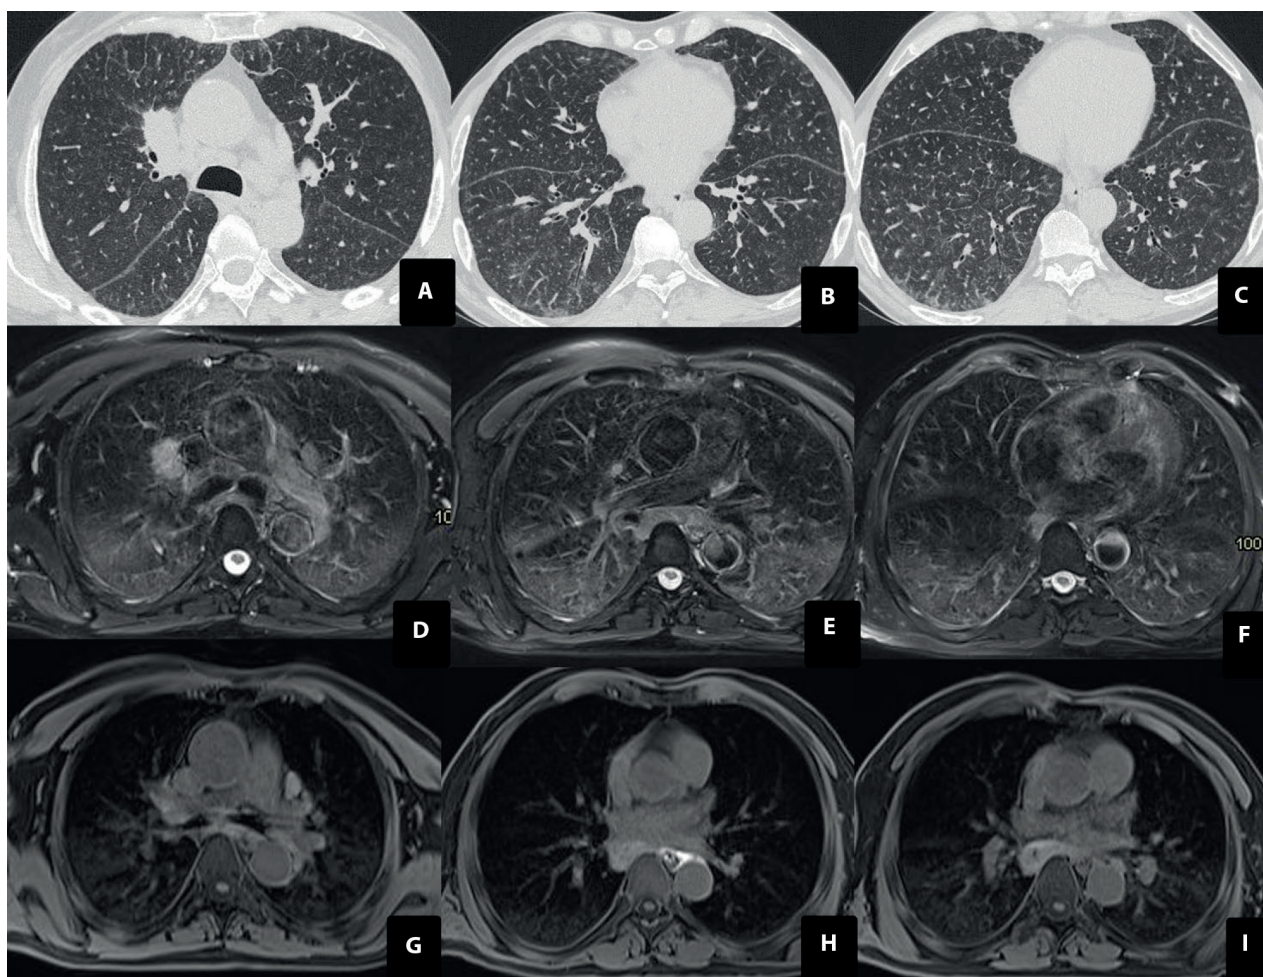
CT scan (a-c): nodular lesion is present in the right hilum, likely related to adenopathy. Mildly, diffusely thickened the interlobular septa, mainly in mid to lower lung zones. Mild alveolar ground glass attenuation is visible in both lower lobes. T2w- MRI (d-f): Adenopathies in the right hilar region, and mediastinum, the biggest in subcarinal region. In both lower lobes is visible a mild increase of the signal, mainly in the left lower lobe (yellow arrow). T1w-MRI sequence with fat saturation (g-i): the first T1 image (g) was acquired before the bronchoscopy and the contrast administration. The second T1-w image (h) was acquired twenty minutes after the end of the bronchoscopy with the contrast medium administration. It shows a minimal amount along the descending aorta. Finally, the last T1-w image was acquired one hour after the procedure, and shows findings similar to the baseline. No evidence of thickened or enhanced interstitium.
